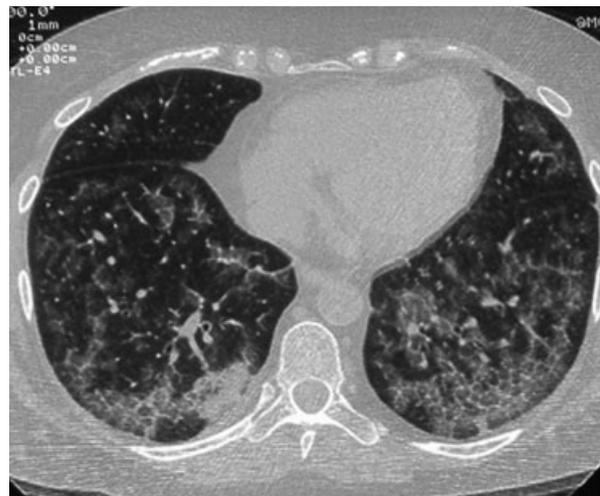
Computed tomography of the thorax showing ground-glass opacification, with polygonal shapes a pattern commonly referred to as 'crazy paving' typically seen in pulmonary alveolar proteinosis.
